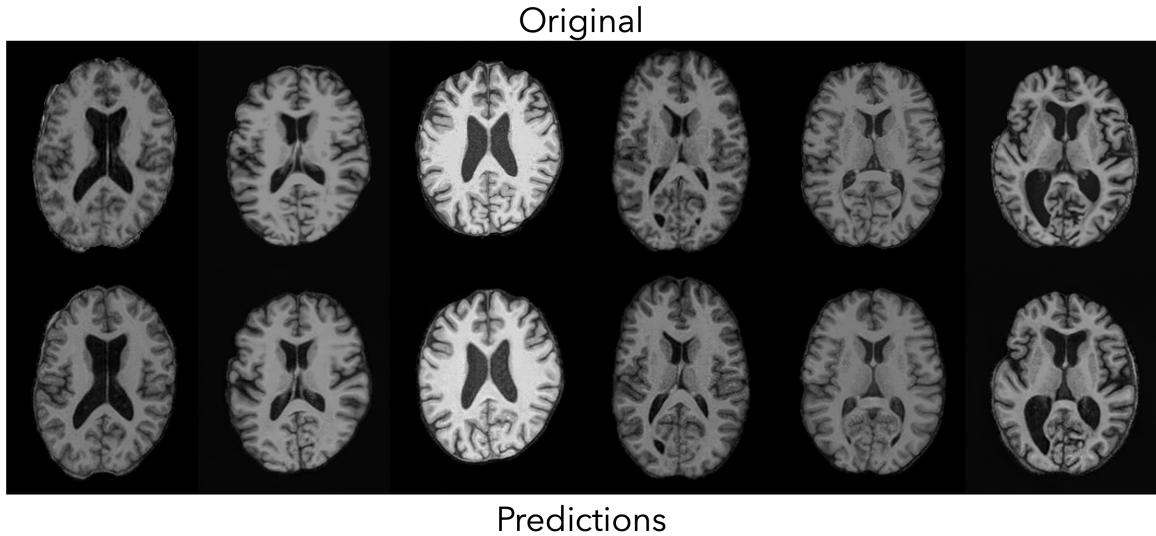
Visual Comparison of Original T1w MRI Scans and Reconstructed MRI Scans after Quantization Using the Proposed LCVQ Approach.
